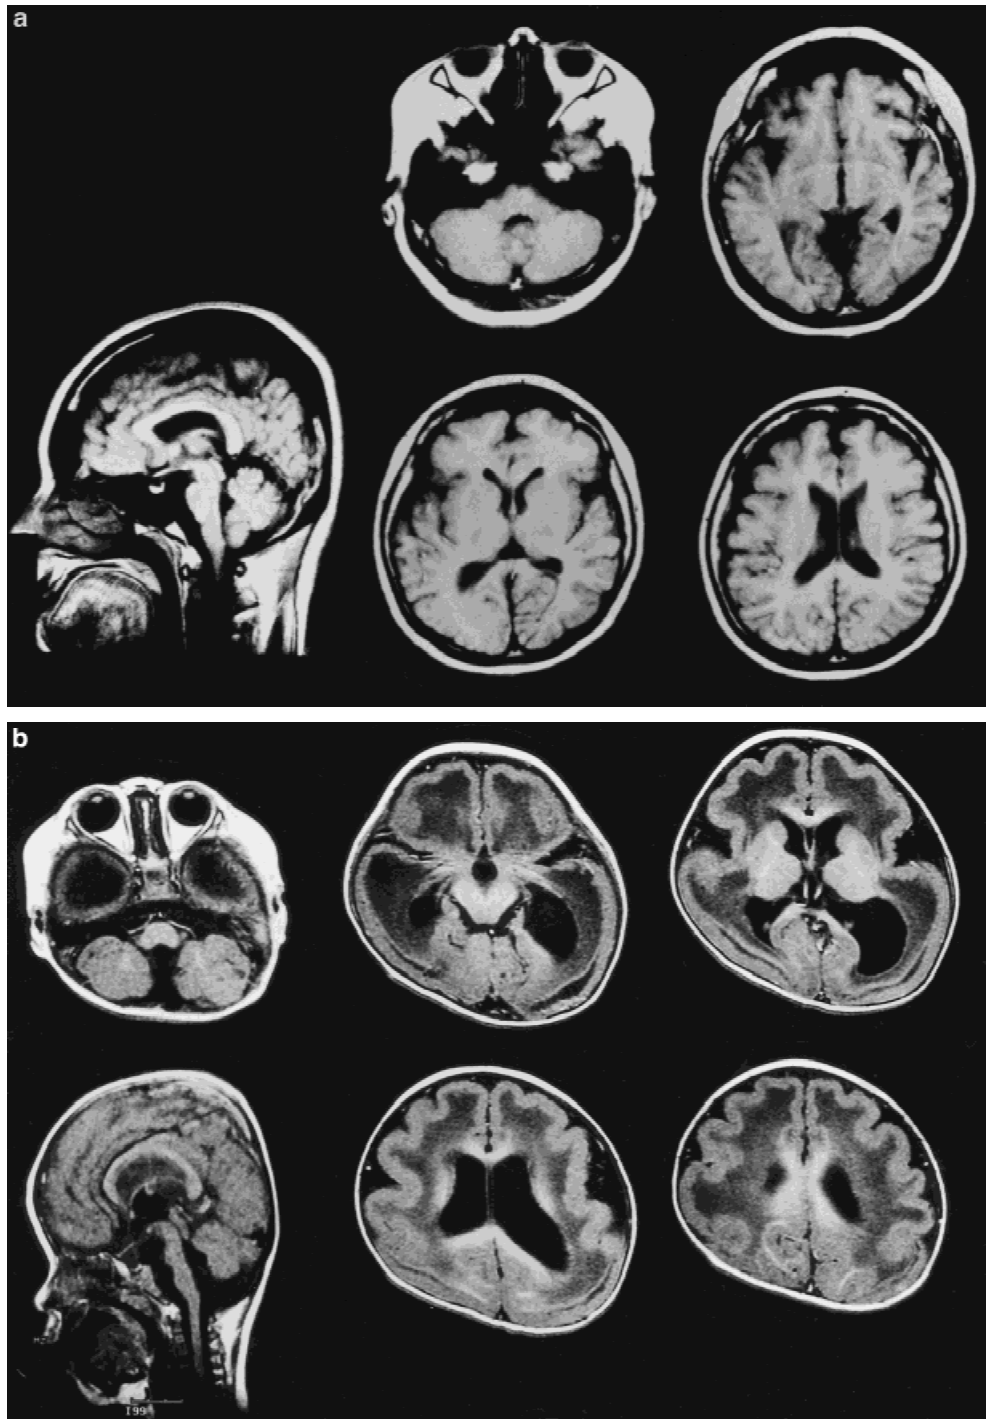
Shown are the brain MRI (T1-weighted image) of FCMD patients. Gyral abnormalities of a milder degree and mild ventricular dilatation but no brain stem hypoplasia in a patient (Case 2) with the mild phenotype (a), and severe gyral abnormality with double cortex in occipital area, ventricular dilatation, and brain stem hypoplasia in a patient (Case 16) with the severe phenotype (b).
